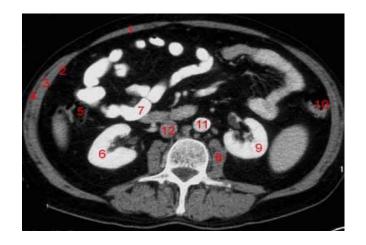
Axial CT of the anterior abdominal wall. (ÖZTOPRAK et al,2009)
